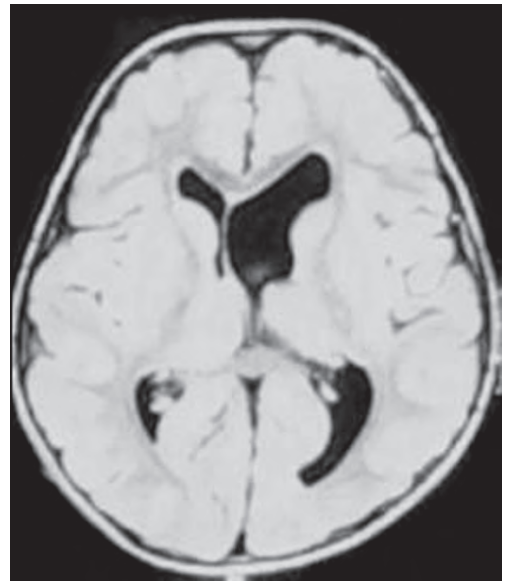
MRI of the brain, axial T1W image showing asymmetrical ventricles
